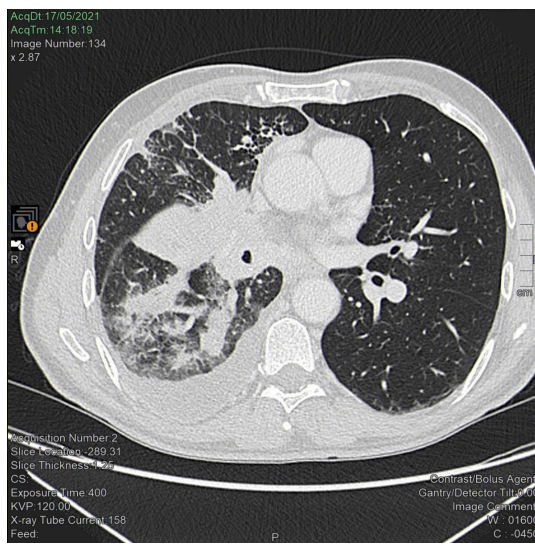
Computed tomography scan of the lungs after 3 months of treatment with pembrolizumab. A considerable reduction in the size of the hilar tissue is apparent 3 months after pembrolizumab initiation. The middle lobe has re-expanded and the apical segmental bronchus of the lower lobe is newly patent. Parenchymal localizations have disappeared from the lower lobe and upper lobe lymphangitis has lessened.
